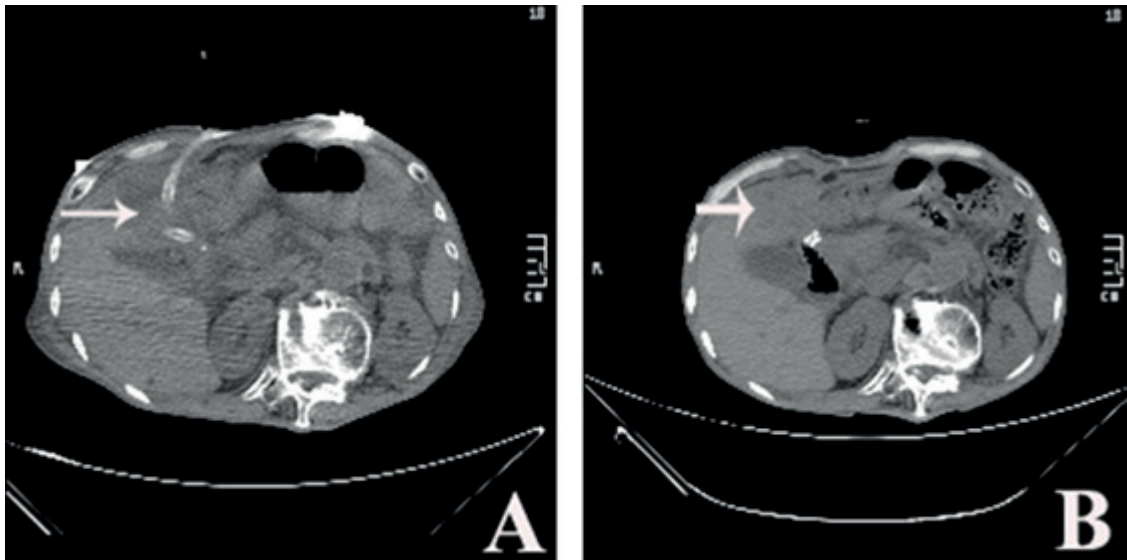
Postoperative imaging studies with abdominal CT scan. A, 7th day; B, 18th day. The site of liver abscess was outlined by white arrows.
